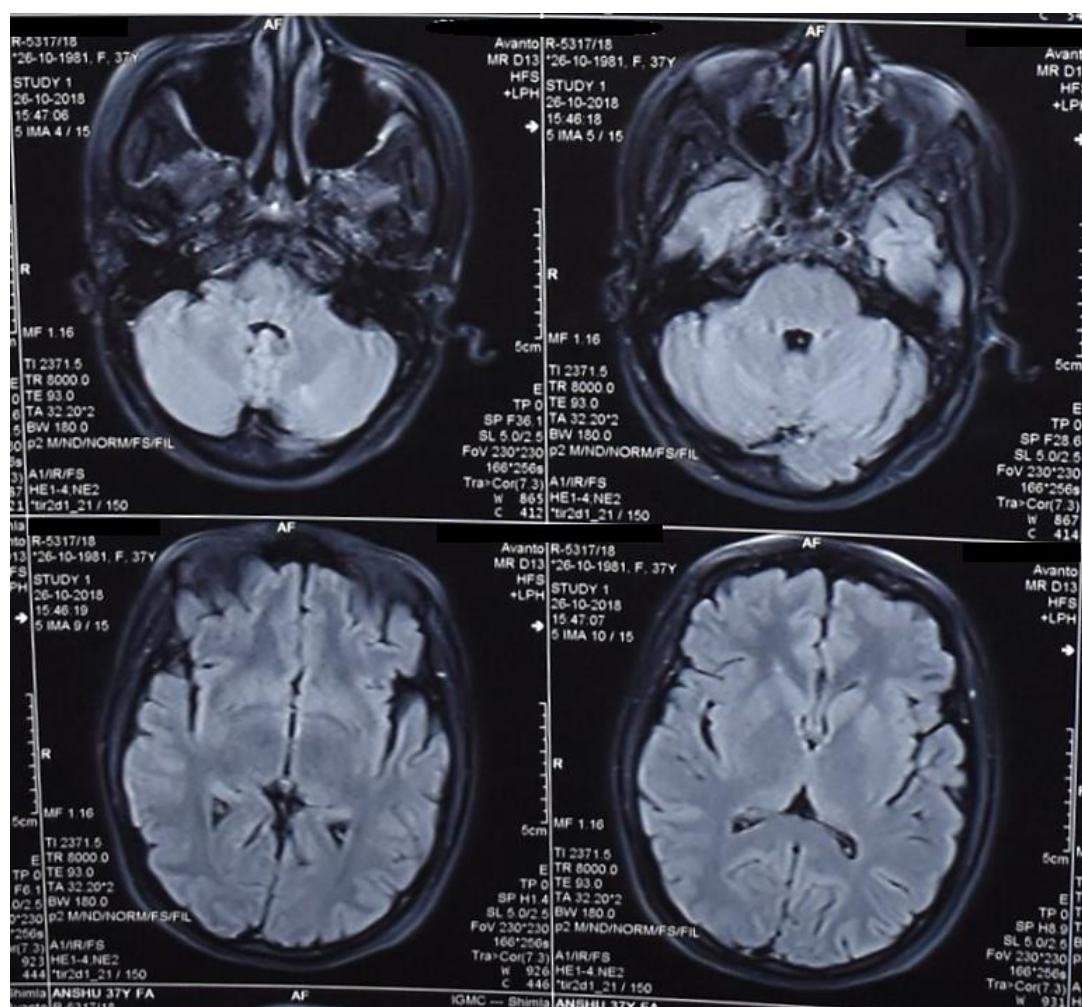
MRI scan showing ischemic changes in midbrain and pons.
